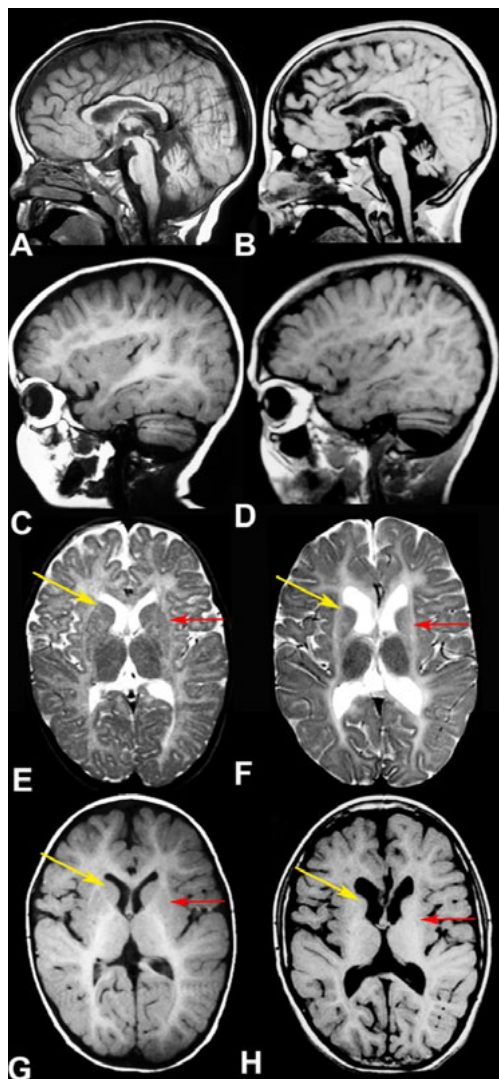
MRI findings in a typical H-ABC patient. Sagittal T1-weighted (A–D) and axial T2-weighted (E and F) and T1-weighted (G and H) images in Patient HA23 with the common c.745G>A mutation at the age of 1.5 years (A, C, E and G) and 13 years (B, D, F and H).
